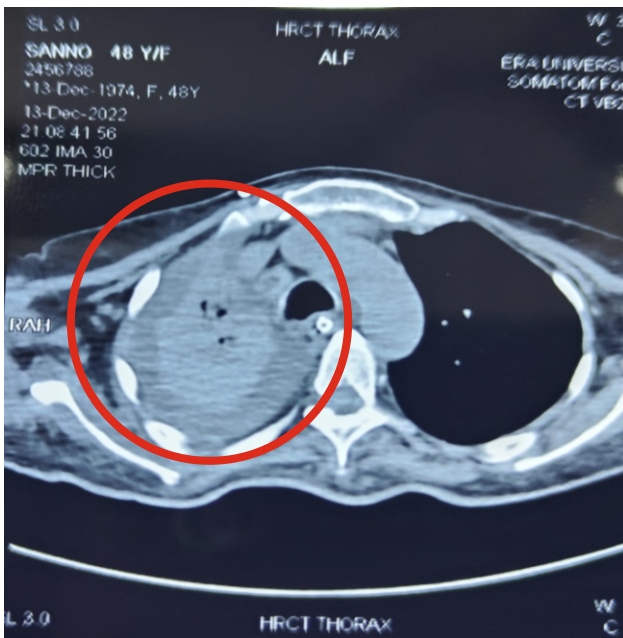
HRCT Thorax section showing Collapse of right Lung
